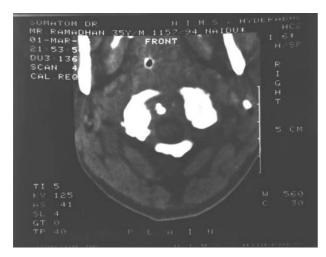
Computed tomogram axial section delineates the destruction of the odontoid and there is increased prevertebral soft tissue
